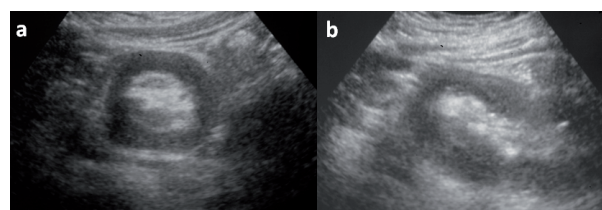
Abdominal ultrasound showing an abnormal loop of bowel in the right iliac fossa with (A) a "doughnut" sign on transverse section and (B) a "pseudokidney" on longitudinal scan. Appearances are characteristic of intussusception
